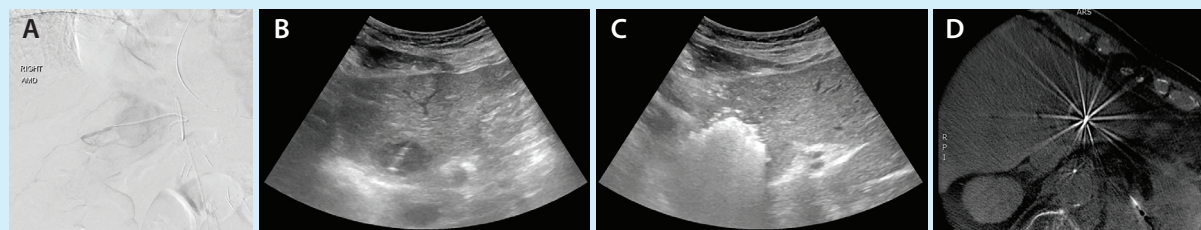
Combined hepatic bland embolization and thermal ablation. Angiography demonstrates a hypervascular tumor in the left lobe supplied by the left hepatic artery and replaced to the left gastric artery (A). Intraprocedural ultrasound demonstrates the probe within a portion of the tumor (B) and echogenic foci during the thermal ablation (C). Intraprocedural cone-beam CT demonstrates the ablation probe centered within the hyperdense embolized tumor (D).
